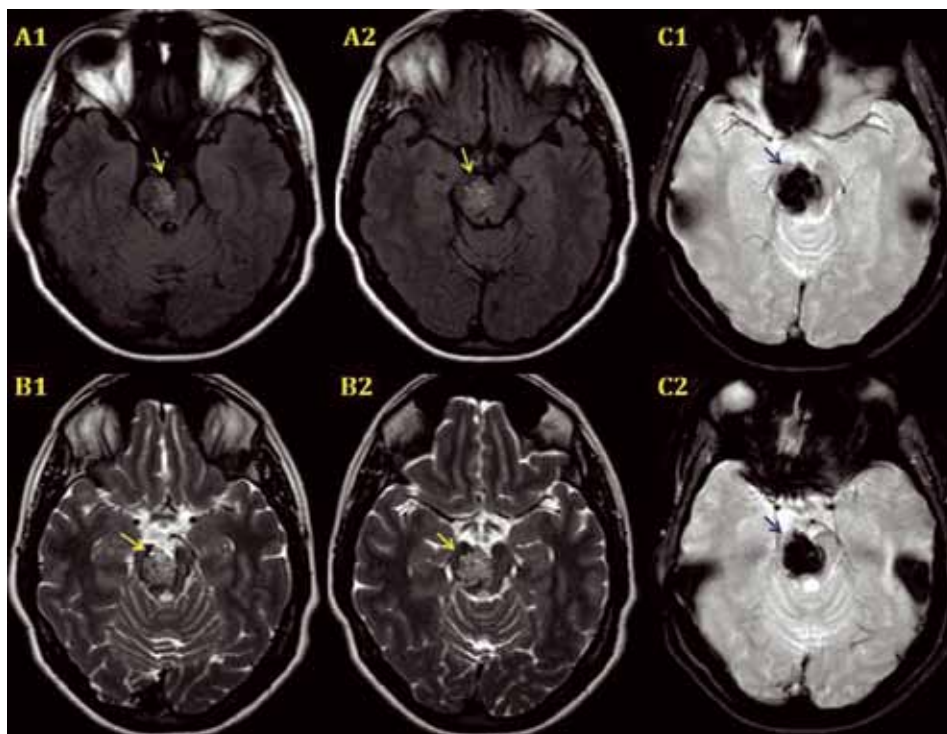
Axial MRI showing a right mesencephalic cavernoma (arrows) (A1/A2: FLAIR-Weighted; B1/B2: T2/TSE- Weighted; C1/C2: EPI-Weighted).
